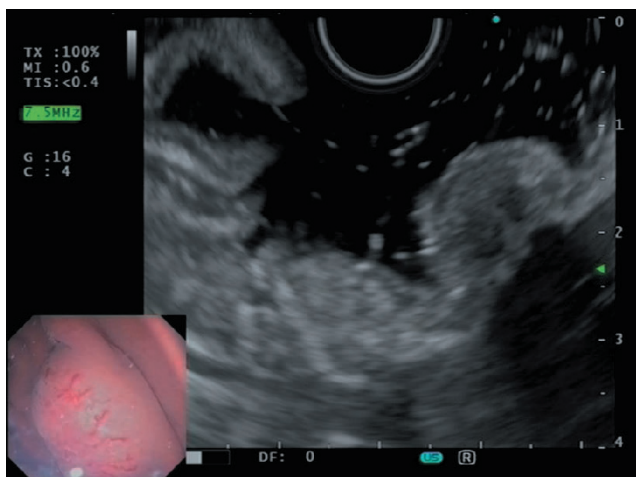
Endoscopic image and endoscopic ultrasound image of a type 2 gastric neuroendocrine tumor
